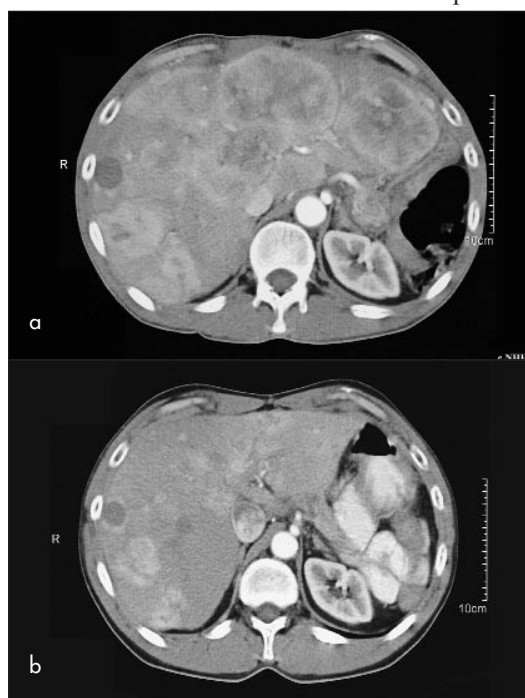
Post-arterial phase computed tomography films (a) pre and (b) post two courses of yttrium-90-octreotide.
